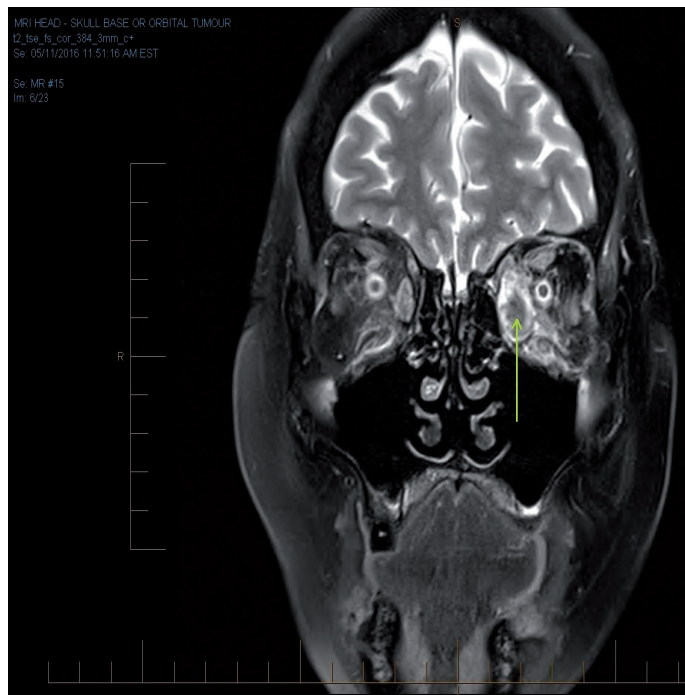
Coronal T2 fat suppressed MRI of the brain and orbits post steroid treatment showing persistent, severe swelling of the left medial rectus with enhancement.
